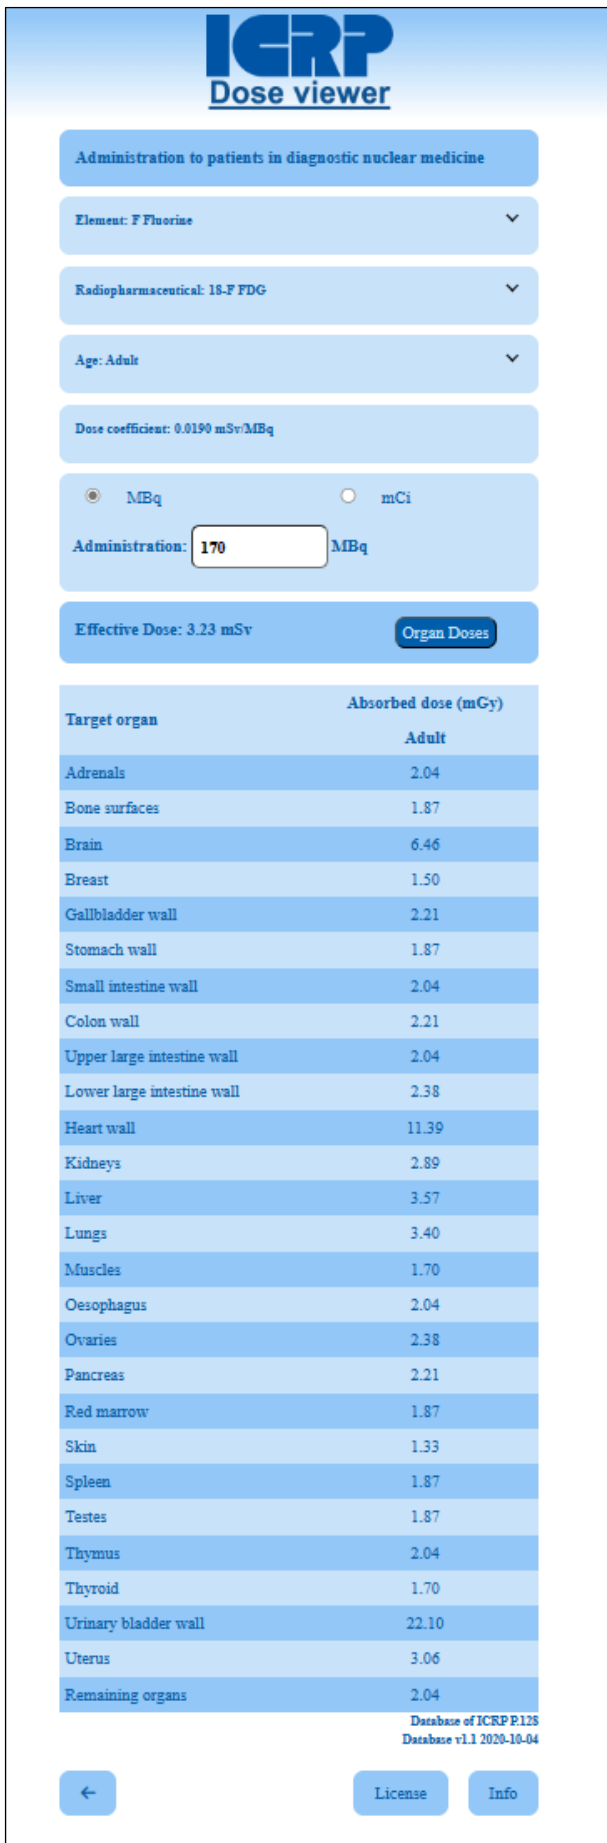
The app also shows the corresponding organ absorbed doses for an injection of 170 MBq of ¹⁸F-FDG.
